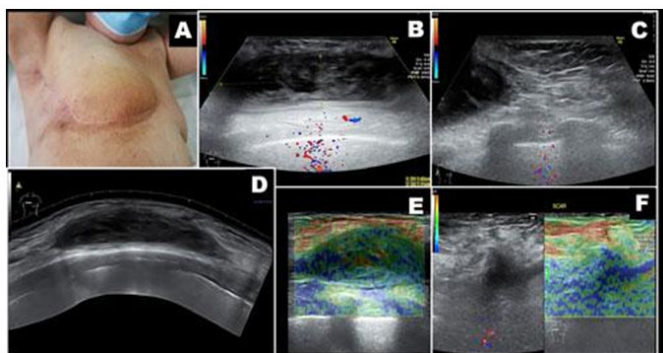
FBU at six-months follow-up: note the inflammatory changes of the superficial small parts in the right-anterior thoracic area (A), and the retro-pectoral heterogeneous fluid collection in real-time US (B, C) and panoramic view (D), with benign aspect of Doppler and SSE (E, F).
